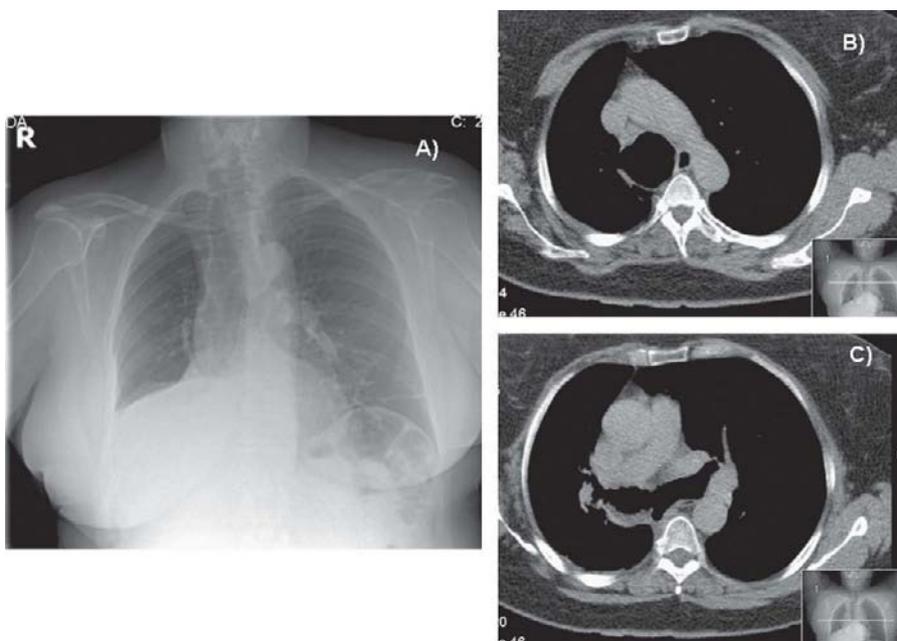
A) Chest X-ray showing atelectasis in the right lower lobe and enlargement of the tracheal air column. B) Computerised axial tomography showing a large increase in the diameter of the trachea, with thinning of the walls and pseudodiverticula. C) Computerised axial tomography showing a major enlargement of the main bronchi.
